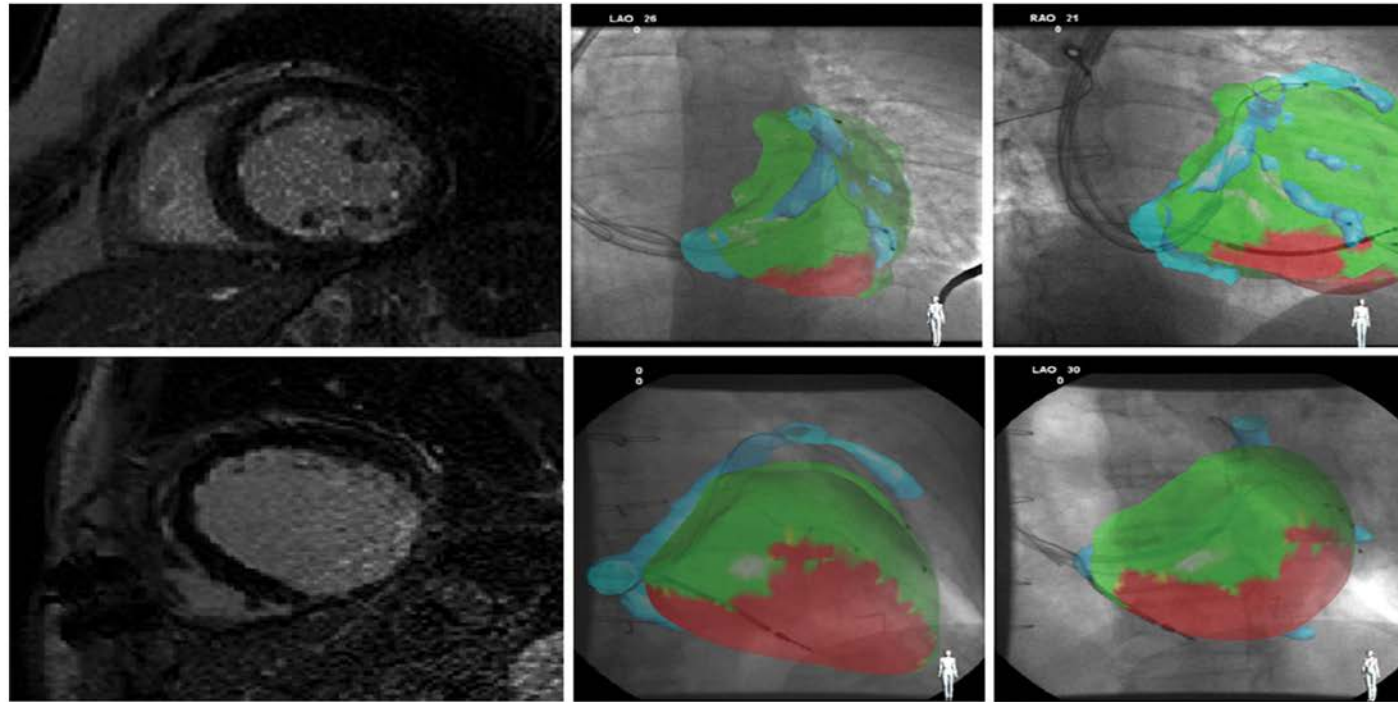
Relationship of scar segmented from cardiac magnetic resonance imaging to lead position on fluoroscopy. *Left panel:* left anterior oblique projection; *right panel:* right anterior oblique projection. *Green shell* indicates three-dimensional left ventricular geometry; *red area* is scar in postero-lateral region. LV1 is seen to be positioned in the region of scar whereas LV2 lead is remote from scar. (Reprinted with permission from:
